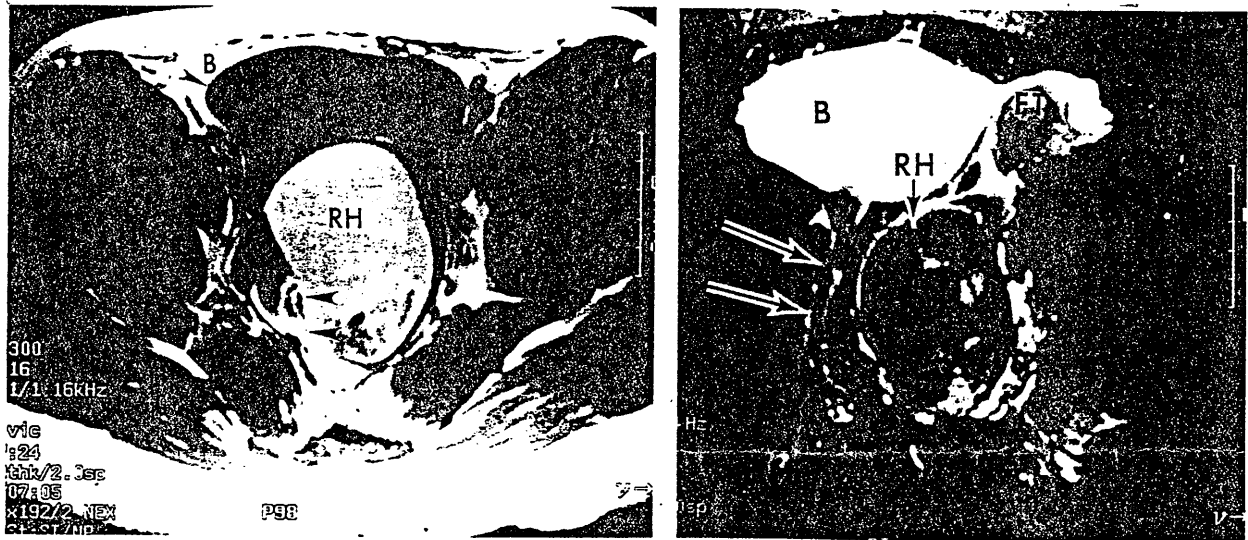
Magnetic resonance images of the pelvis identify an obstructed left rudimentary horn (RH) and a smaller, thin right hemiuterus (arrows). Bladder (B) and fallopian tube (FT) are also shown.
